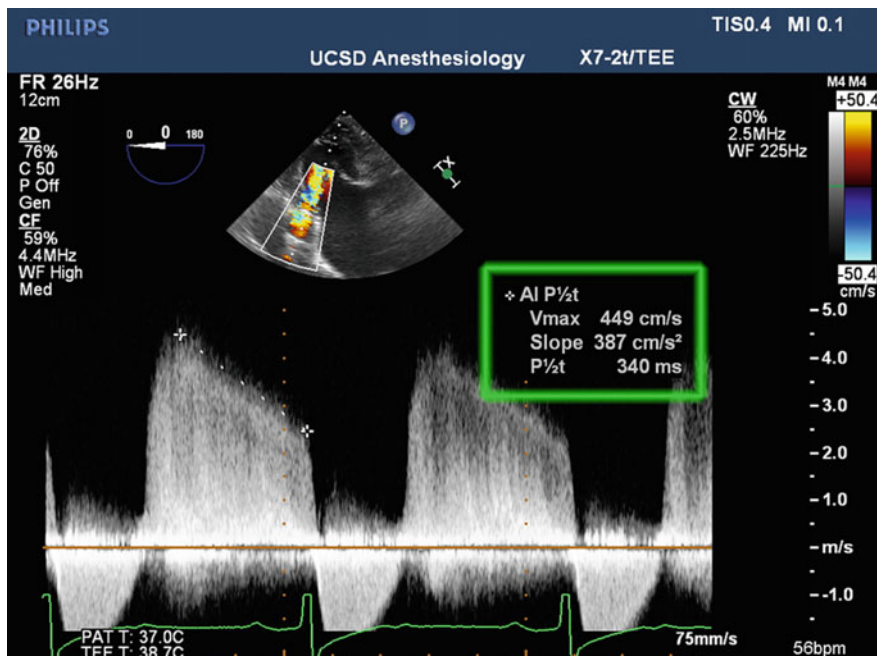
Aortic valve pressure half time: a deep TG LAX view is obtained to align the continuous wave Doppler beam parallel to the flow into the LVOT. The peak velocity (V_{max}) of the regurgitation is the starting point for the measurement of the jet’s pressure decay. The PHT is then calculated –340 ms (moderate aortic regurgitation)
